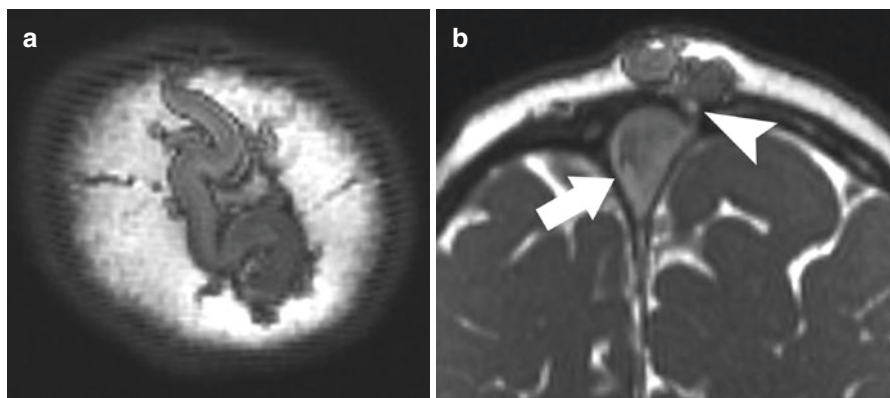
Heavily T2-weighted CISS images in a 1-month old with a scalp mass. (a) The axial image shows a prominent subgaleal varicosity with small venous tributaries. (b) The intra-osseous vein (*arrowhead*) and its connection with the superior sagittal sinus (*arrow*) are well demonstrated on the coronal image
